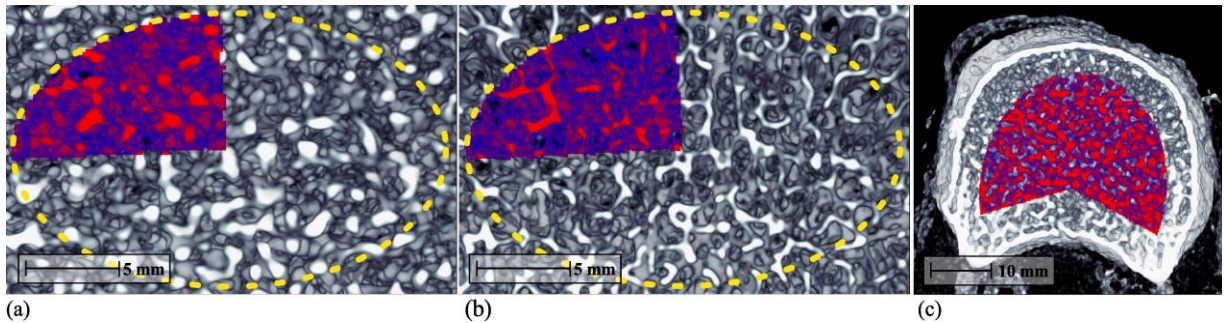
Transversal ray-tracing projection of the vertebral CT-scans. (a) Embedded vertebra subvolume from HRQCT scan and representative cylindrical VOI with one of four sub-VOIs, (b) corresponding HRpQCT scan, (c) HRQCT BioAsset scan with one Pacman-shaped VOI per vertebra.
